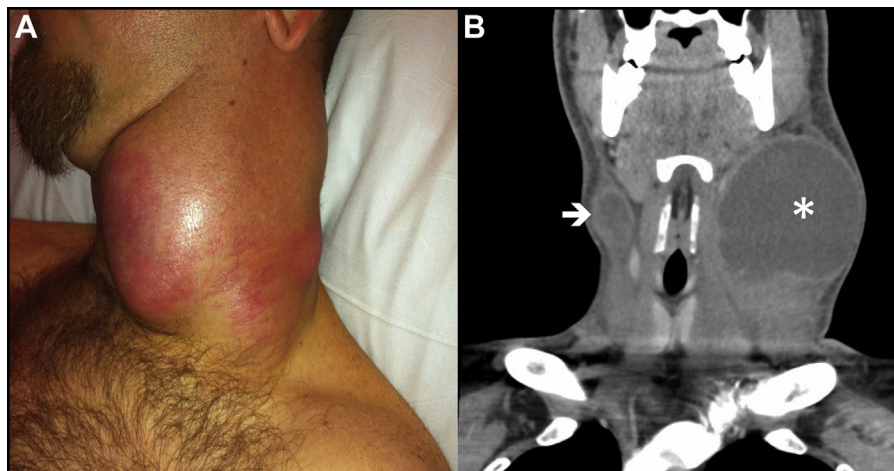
(A) Photograph of patient on presentation with large nontender left-sided neck mass. (B) Neck computed tomography scan showing left (*asterisk*) greater than right (*arrow*) centrally hypoattenuating cervical lymphadenopathy. The left cervical lymph node shown measures approximately 8 cm in diameter.
